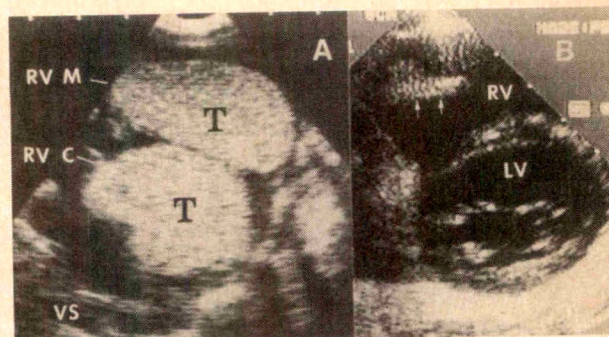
Two-dimensional echocardiogram of patient 2. (A) Modified short-axis view of the right ventricular cavity (RV C) obtained at 1 day of age reveals a large cavity as well as a well-circumscribed intramural mass. (B) Follow-up study at 3.5 years of age reveals complete resolution of masses and only an echodense area (white arrows) of the papillary muscle remains. LV = left ventricle; RV = right ventricle; RVM = right ventricular mural; T = tumor; VS = ventricular septum.
